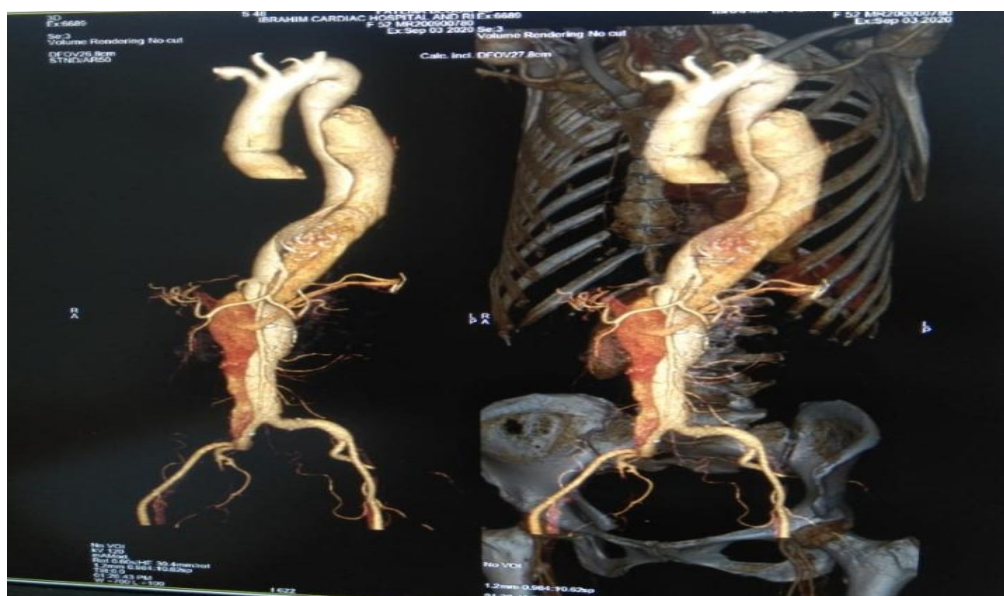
Computerized tomography (CT) angiogram study of the aorta and its branches shows elongated intimal flap extended from upper descending aorta up to right common illiac vessel, causing a long dilated false lumen which compress the adjoining true abdominal aortic lumen. Long mural thrombus is seen in false lumen from lower descending aorta to right common iliac arteries (CIAs). In thoracic part, false lumen shows curvilinear wall thickening. Maximum diameter of false lumen is 53 mm and seen in lower thoracic and mid abdominal aortic level.
